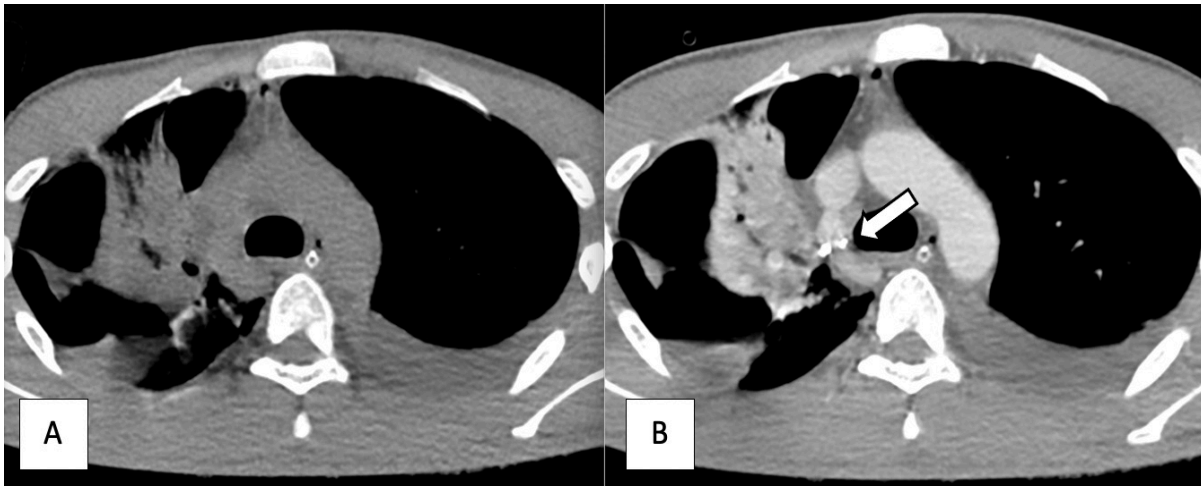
(A) Axial CT at the level of mid thorax in non-contrast and (B) contrast. In the contrasted image, there are multiple high-density foreign bodies which were not visualized in non-contrast study (white arrow) adjacent to the azygos vein associated with surrounding fat streakiness.
